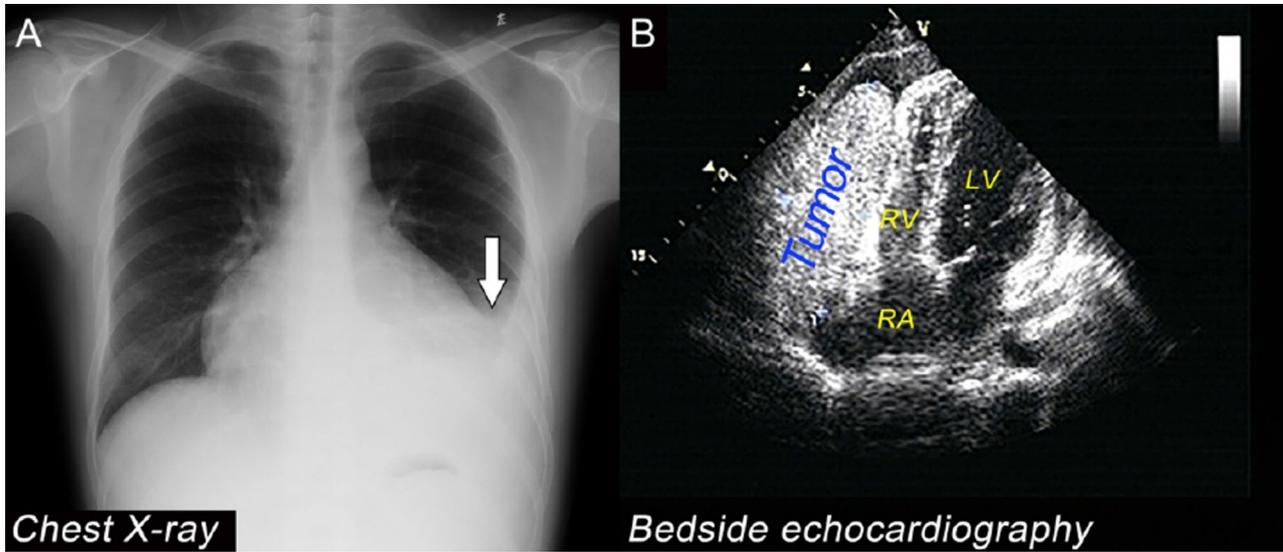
Chest X-ray (A) and bedside echocardiography (B). Chest X-ray (PA view) showing left pleural effusions (white arrow) and marked enlargement of the cardiac silhouette, which is the so-called “water bottle sign.” Bedside echocardiography showing a mass in the pericardium, which was adjacent to the anterolateral wall of the right ventricle with an unclear boundary on the four-chamber view.
